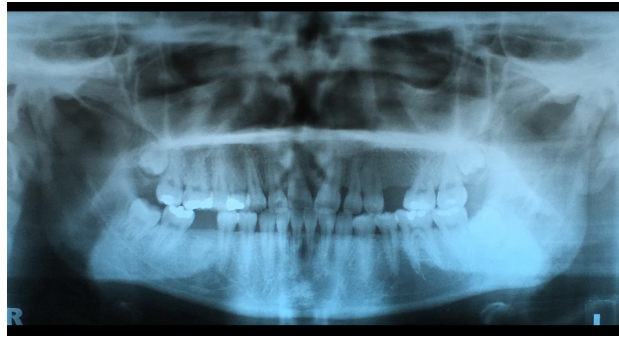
Pretreatment panoramic radiograph showing missing maxillary left premolars and mandibular right first molar, mesial tipping of the adjacent molars, absence maxillary antrum, and the unerupted maxillary third molars
